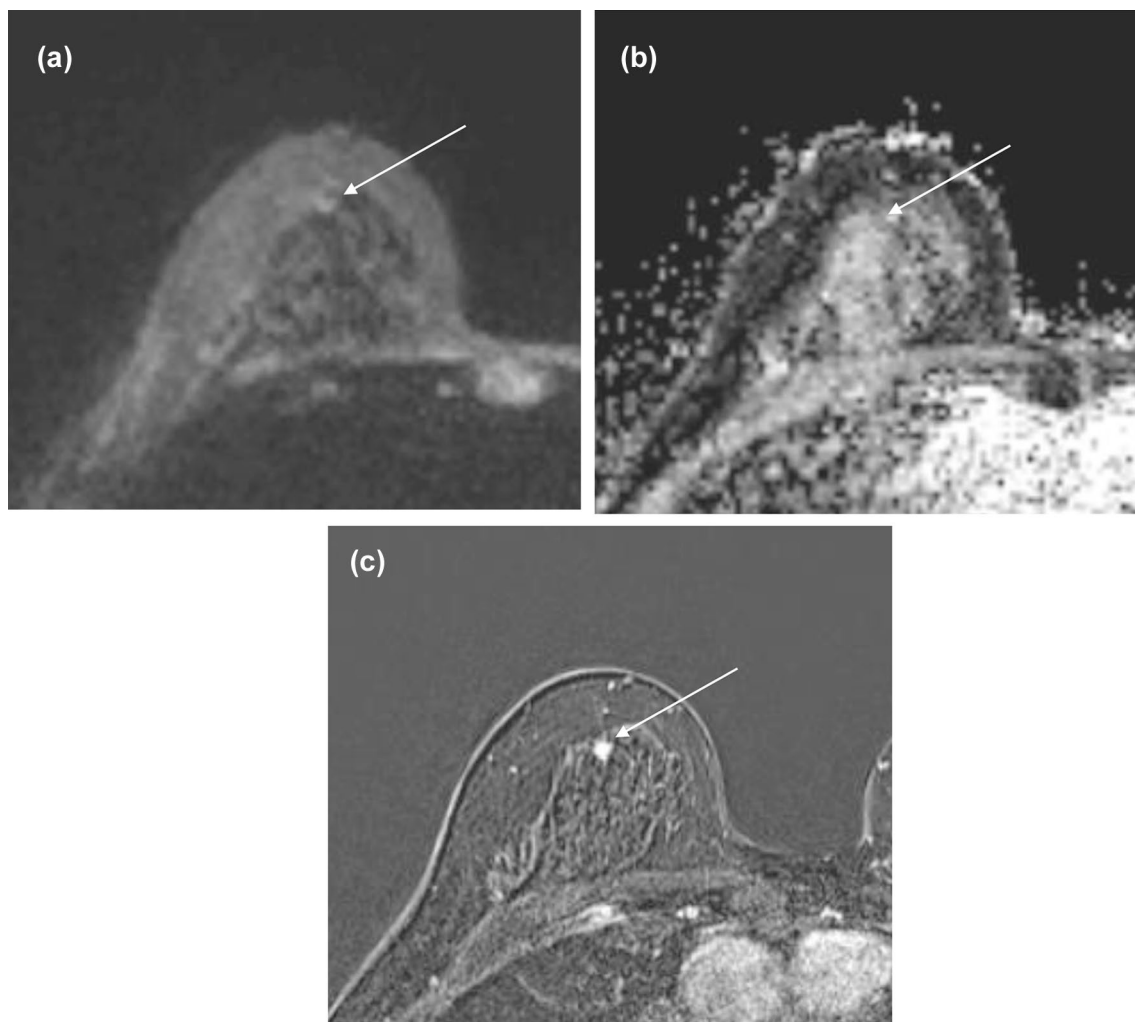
A 44-year-old woman with invasive ductal carcinoma in the right breast. a Axial image from diffusion-weighted (DW)-MRI ( $b=1000 \text{ s/mm}^2$ ) shows a round mass (arrow) with high signal intensity. b On the apparent diffusion coefficient (ADC) map, the mass (arrow) shows low mean ADC ( $1.02 \times 10^{-3} \text{ mm}^2/\text{sec}$ ). c Axial T1-weighted subtraction image from dynamic contrast-enhanced (DCE)-MRI shows a 5 mm irregular heterogeneous enhancing mass
